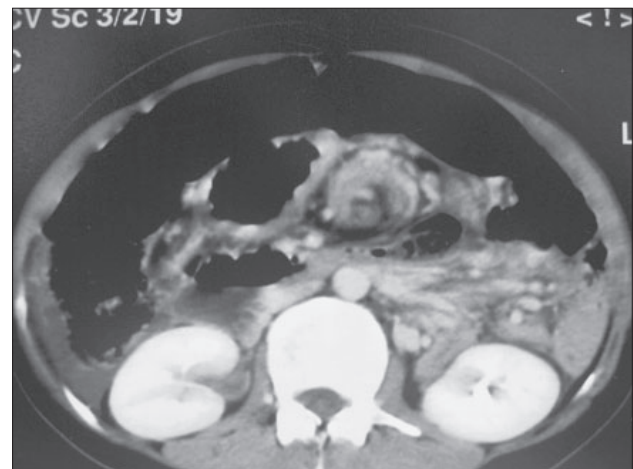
Abdominal CT showing the spleen that is not in its normal location.
